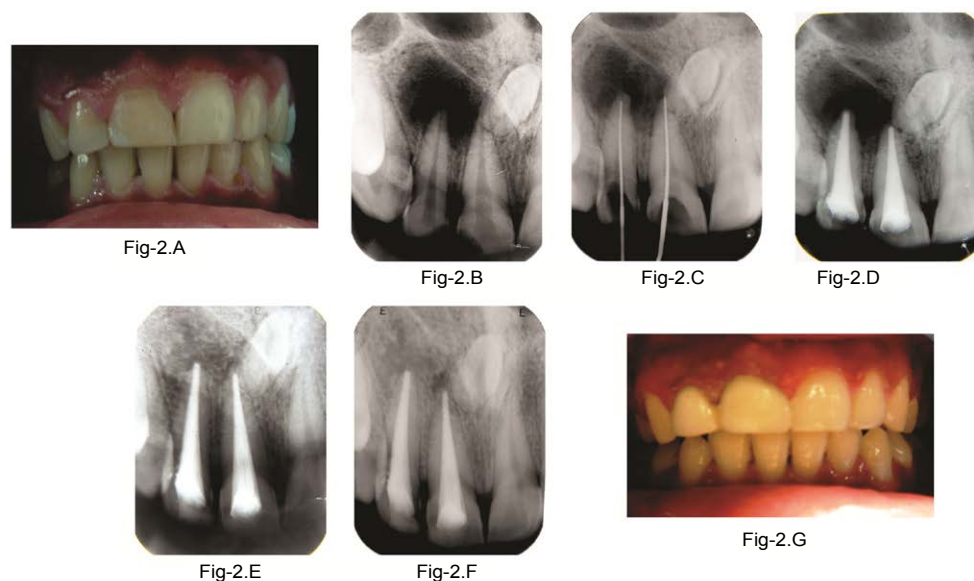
A: Preoperative photograph of the tooth # 11 and 12; B: Preoperative radiograph of the tooth # 11 and 12; C: Working Length determination radiograph; D: Radiograph after successful obturation of the tooth; E: Follow up radiograph of the teeth after 6 months; F: Follow up radiograph of the teeth after 12 months; G: Photograph after Prosthetic rehabilitation of tooth with PFM crowns.
